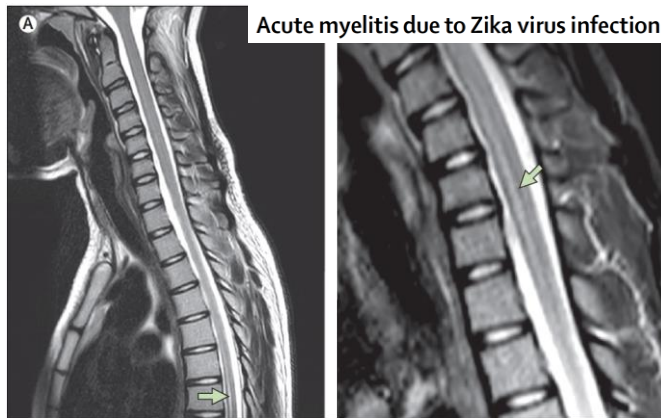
Magnetic resonance imaging (MRI) showing myelitis in Zika virus infection
